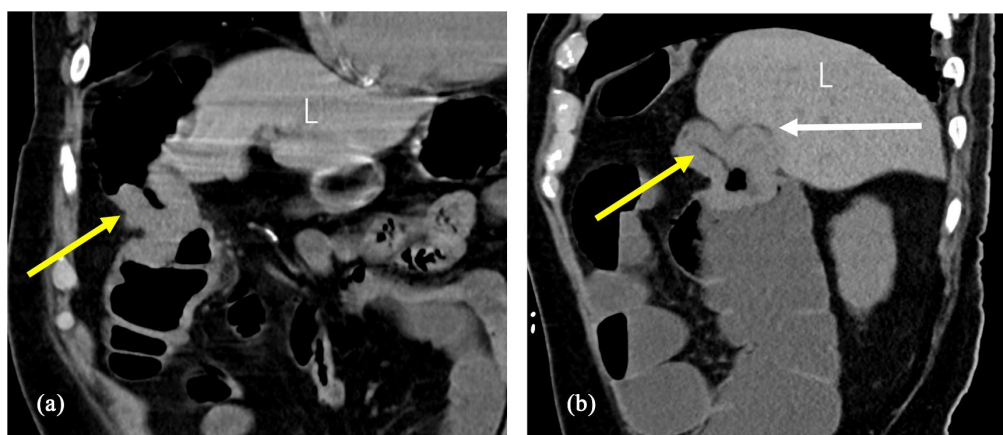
(a) Coronal CT noncontrast image showing a 4 cm. mass within the ascending colon about the hepatic flexure (yellow arrow). Liver (L). (b) Sagittal CT noncontrast image of the mass in the hepatic flexure (yellow arrow) invading the adjacent collapsed gallbladder (white arrow).
